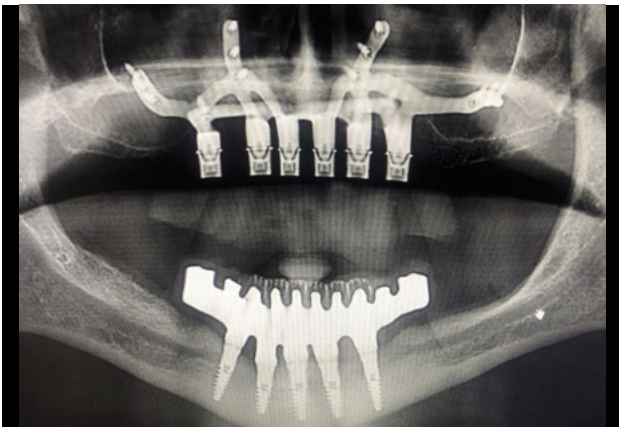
Orthopantomography with SI and provisional prosthesis.
